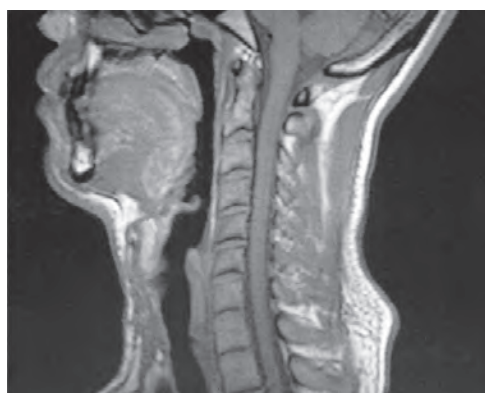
An axial view of the magnetic resonance imaging scan showing squamous cell carcinoma of the trachea.
